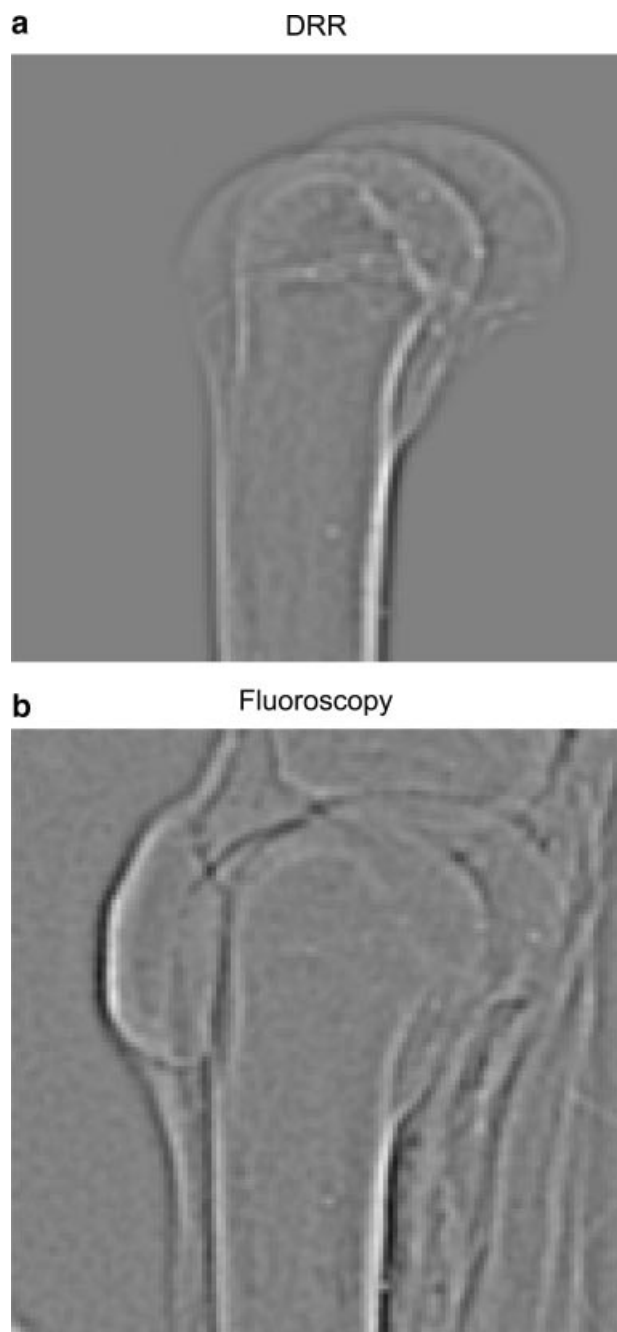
Edge-enhanced versions of (a) the 2D digitally reconstructed radiograph (DRR) produced from the CT volume of the femur and (b) the distortion-corrected fluoroscopy frame.
